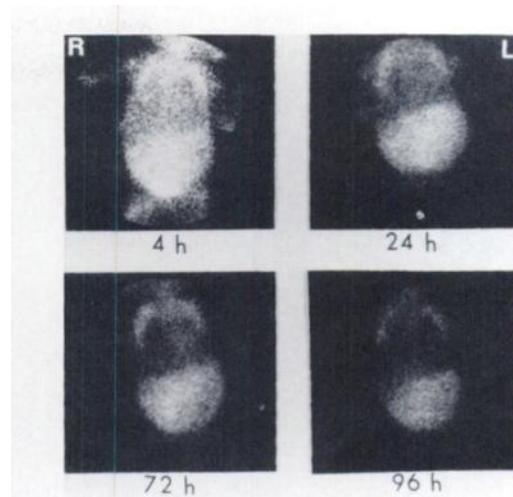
Anterior scintigrams of chest and abdomen at 24, 72, and 96 hr after injection of Ga-67 citrate show persistent diffuse abnormal radioactivity in abdomen, indicating peritonitis. Note minimal radioactivity in liver. Intense activity in thoracic cage is believed due to overlapping rib activities.
